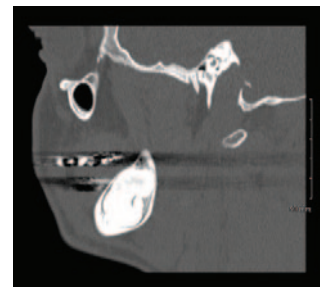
CT sagittal view.
